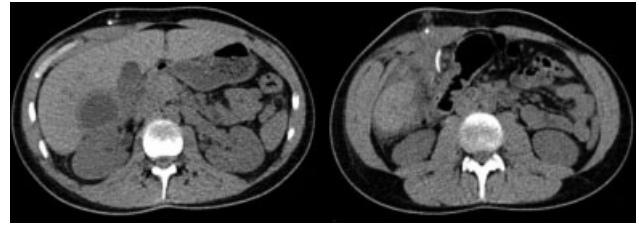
Control abdominal computed tomography scan showing resorption of more than 70% of the hepatic cyst
